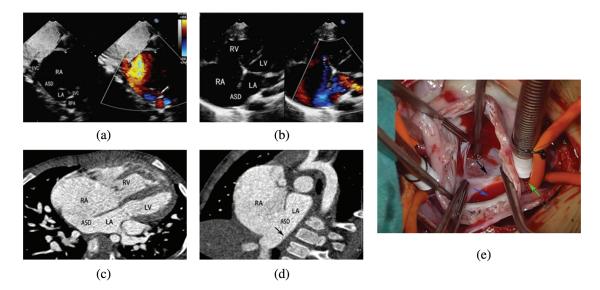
Inferior SVD with no posterior atrial rim and right pulmonary vein connected to RA. (a) Subcostal sagittal echocardiographic view demonstrated atrial septal defect adjacent to inferior vena cava. (b) Apical four-chamber view. ASD was in posterior region of atrial septum, with no residual posterior atrial septal tissue. (c) There was no posterior interatrial septal rim between ASD and posterior atrial wall in CT imaging. (d) Multiple-planar reconstruction CT demonstrated ASD without posterior atrial rim was adjacent to inferior vena cava. (e) Surgical findings. Opened-up RA showed that an inferior SVD was adjacent to inferior vena cava (green arrow demonstrates inferior vena cava cannula), with a 'bald' posterior wall (black arrow). Blue arrow indicated residual blood that was originated from anomalous right pulmonary veins. (SVD, sinus venosus defect; RA, right atrium; ASD, atrial septal defect)
